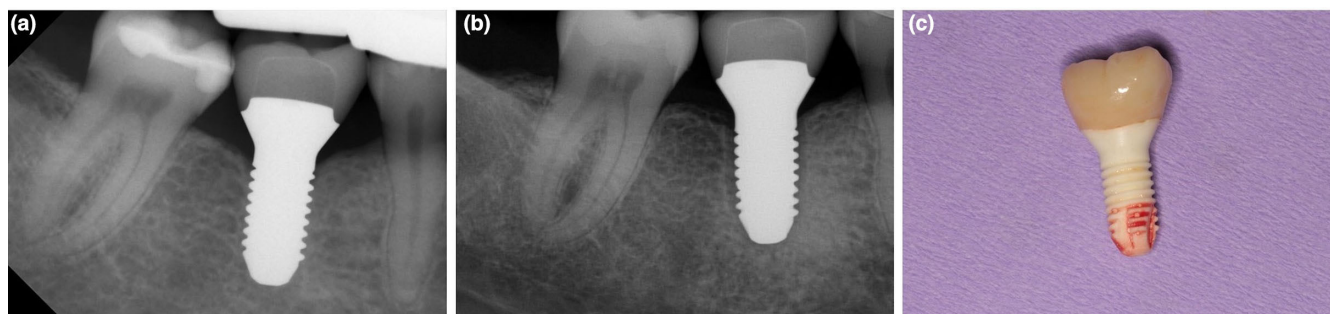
Case of implant failure between 2- and 9-year follow-up. (a) Intraoral radiograph at 6 months after crown fitting confirming implant osseointegration; (b) intraoral radiograph at 110 months after implant placement showing the characteristic peri-implant radiolucency; (c) removed implant. The absence of an adequate contact point after the replacement of the restoration at tooth 37 might have played a role in implant failure.
